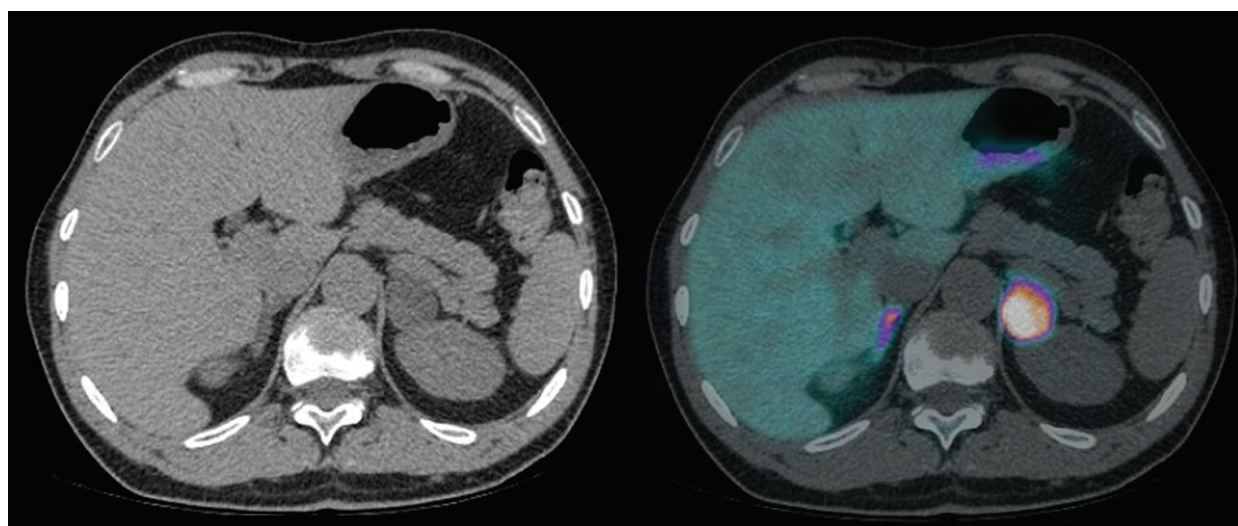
A relatively large nodule (30 mm) in left adrenal gland (CT scan) with high tracer uptake on $(11)\text{C}$ -metomidate PET-CT scan identified as aldosterone-producing adenoma.
